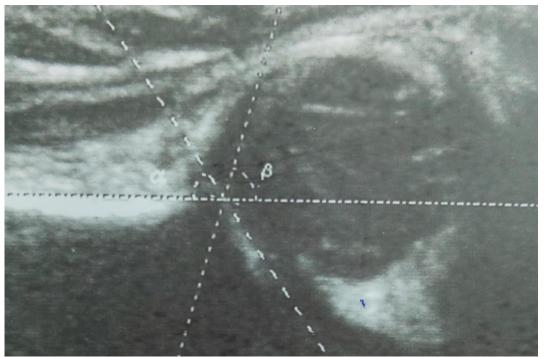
Ultrasound image of a 15 day-old-girl with Graf type-D Hip, showing alpha angle 43 & beta angle 76 (Decentered Hip).
